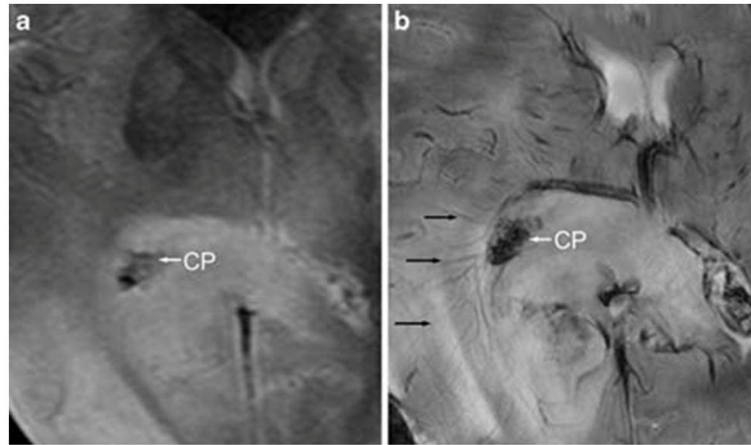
MR images of an axial slice of a human brain at (a) 1.5 and (b) 7 T. The image acquired at 7 T enables visualization of blood vessels (black arrows) and choroid plexus (CP, an abnormality in the right lobe) that are not clearly visible at 1.5 T.⁷ Reprinted from C. Moeninghoff, S. Maderwald, J. M. Theysohn, O. Kraff, M. E. Ladd, N. El Hindy, J. van de Nes, M. Forsting and I. Wanke, Imaging of Adult Astrocytic Brain Tumours with 7 T MRI: Preliminary Results, *Eur. Radiol.*, 2010, 20, 704–713, with kind permission from Springer Science and Business Media.
